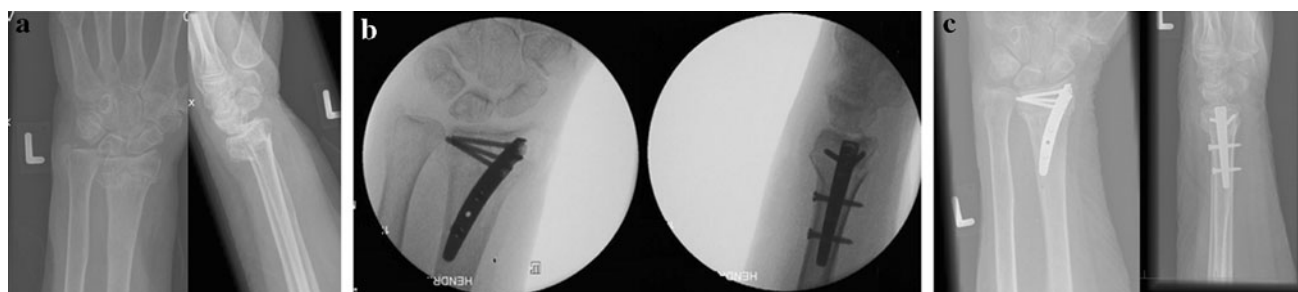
a X-rays of the left wrist in an 88-year-old female, after she stumbled and fell on her left hand/wrist, showing an intra-articular fracture of the distal radius. b Anteroposterior and lateral radioscopic
